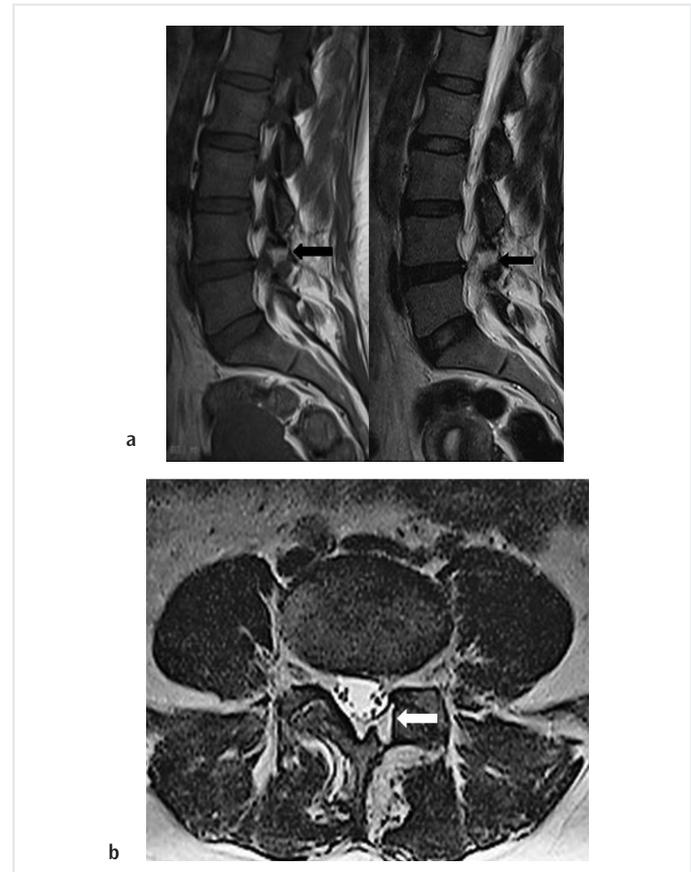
a) Sagittal T1-weighted imaging (T1WI) and T2-WI); b) Axial T2WI showing hyperintense cystic lesion (arrows) in the ligamentum flavum on the left at the L4-L5 intervertebral level
